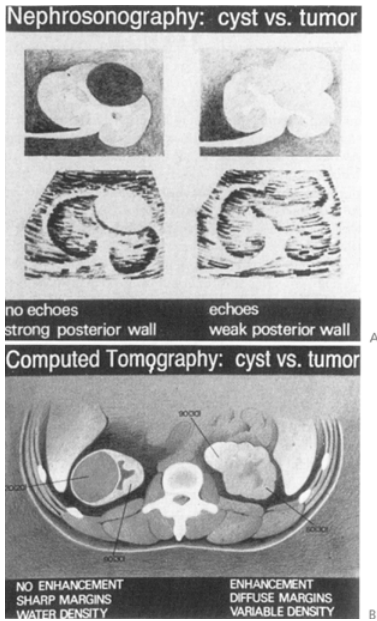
A: Characteristics of cystic (left side) and solid tumorous (right side) renal mass as each would appear on a renal ultrasound study. B: Characteristics of a cystic (left side) and tumor-bearing (right side) kidney as each would appear on a computed tomogram study. Numbers refer to Hounsfield units with and without (in parentheses) intravenous contrast administration.
